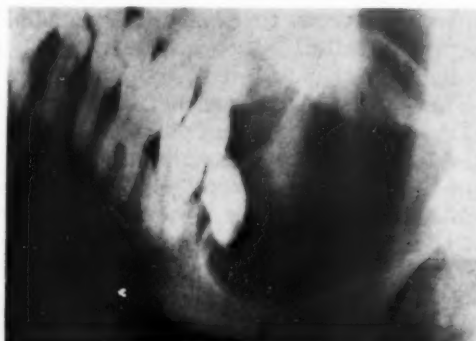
Adamantinoma with atypical x-ray appearance. Unilocular form with a tooth inside the lesion.
